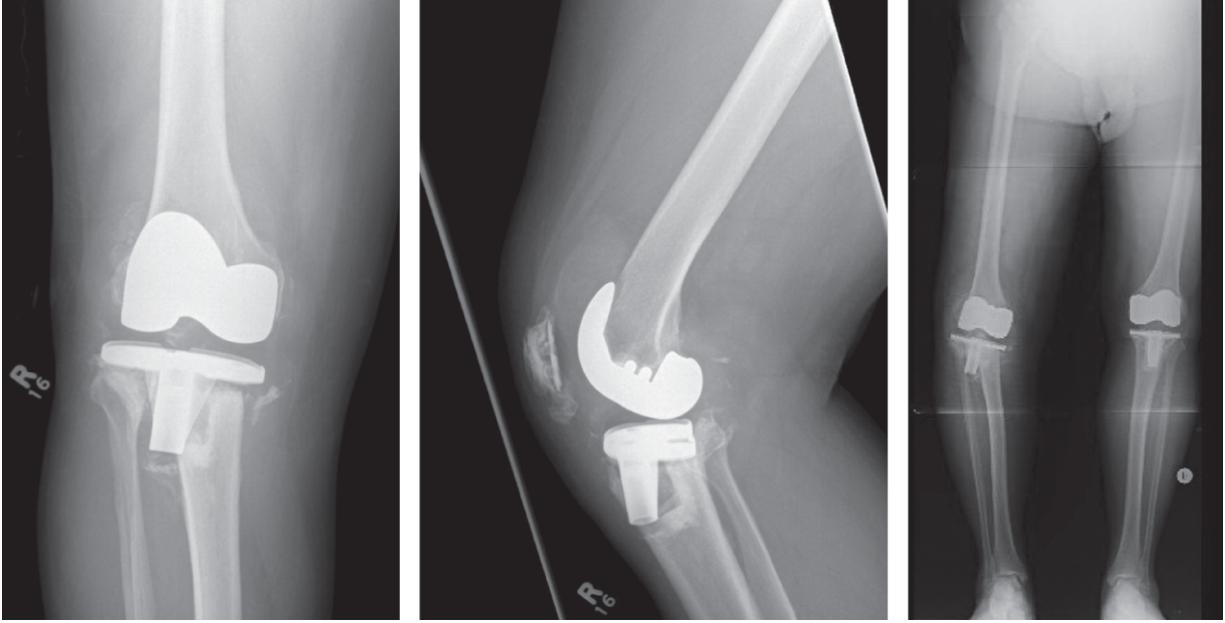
Preoperative radiographs.
